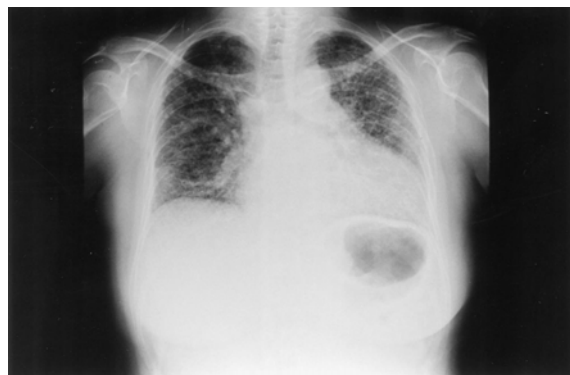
Preoperative chest X-ray showing cardiomegaly and ground-glass shadows in the lung field.
